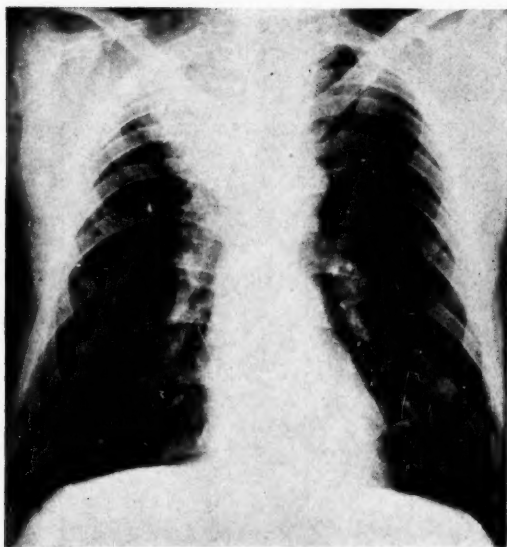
Roentgenogram of chest made in case of man, aged fifty-seven years, who gave a history of cough with expectoration of mucoid secretion, occasionally blood tinged for two and one-half months. Recently there had been a numb sensation about the right shoulder girdle. The cough was worse at night and when lying on the right side. On consulting his physician a roentgen study of the chest was made and he was sent to the Jefferson Hospital. On admission he was afebrile. Roentgenogram revealed a dense infiltrating process involving upper lobe of the right lung. The diagnosis was primary bronchogenic carcinoma. Bronchoscopic examination was negative; however, secretions secured from orifice of right upper lobe bronchus revealed cancer cells. A small node found in the right supraclavicular space was removed for study. The diagnosis was metastatic carcinoma. The case was considered inoperable. (Film by Dr. Paul C. Swenson.)
